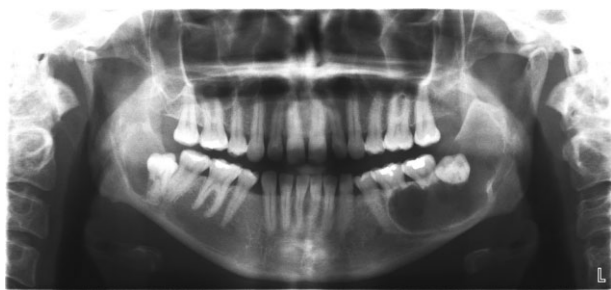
Orthopantomogram demonstrating synchronous bilateral mandibular radiolucent lesions associated with impacted lower wisdom teeth and significant root resorption of the neighbouring molars.
